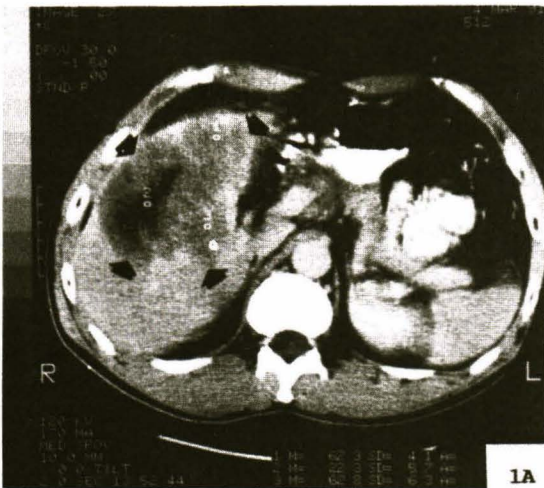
Case 1 contrast enhanced CT upper abdomen shows a large HCC right lobe liver measuring 10 x 7 x 8 centimeters in size (arrow).
